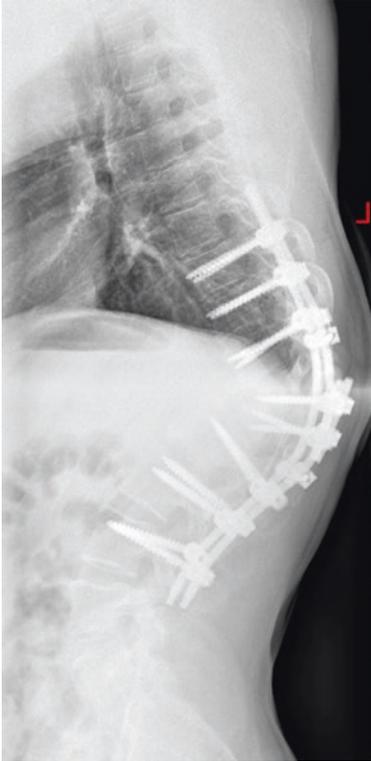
Postoperative x-ray after vertebral column resection. A correction of 50% was achieved. Due to intraoperative loss of neural function that was detected by neuromonitoring, the correction was performed partially
